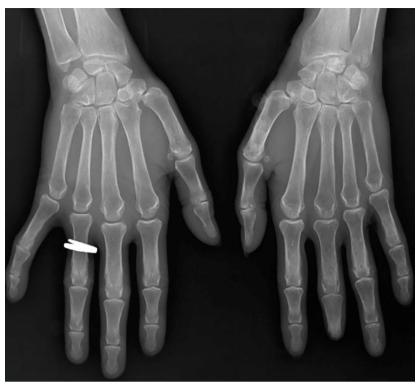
Bilateral palmar X-ray showed no erosion or bone defect. Noticeably, the white mark was golden ring.
